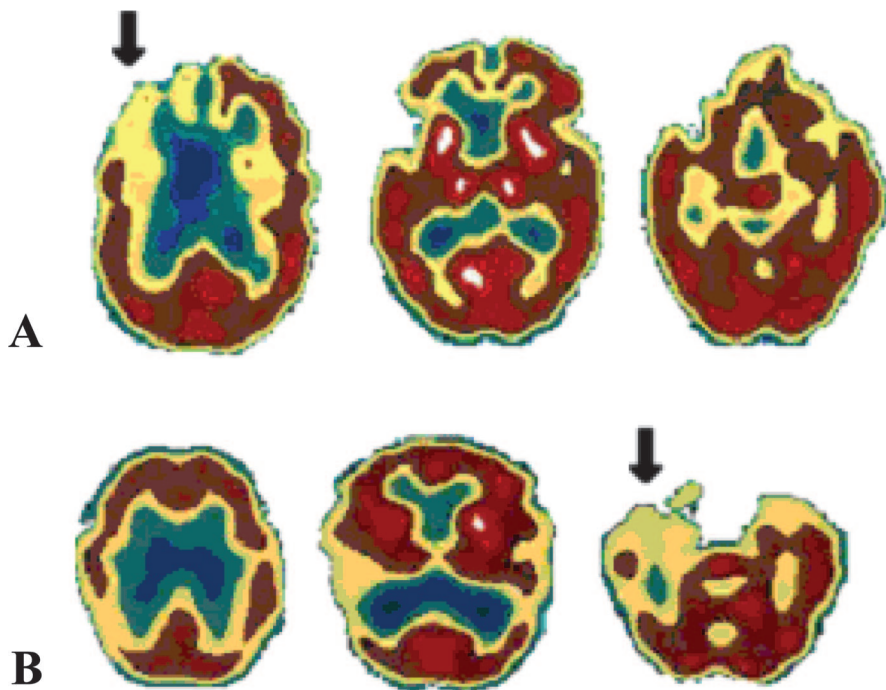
(A) Example of SPECT scan rating on a patient with predominant right frontal hypoperfusion. Lobar ratings were 3 for right frontal, 1 for left frontal, 2 for right temporal, and 1 for left temporal. (Radiology convention: left is on the right side and right is on the left side.) (B) Example of SPECT scan rating on a patient with predominant right temporal hypoperfusion. Lobar ratings were 1 for right frontal, 1 for left frontal, 3 for right temporal, and 1 for left temporal. (Radiology convention: left is on the right side and right is on the left side.)
